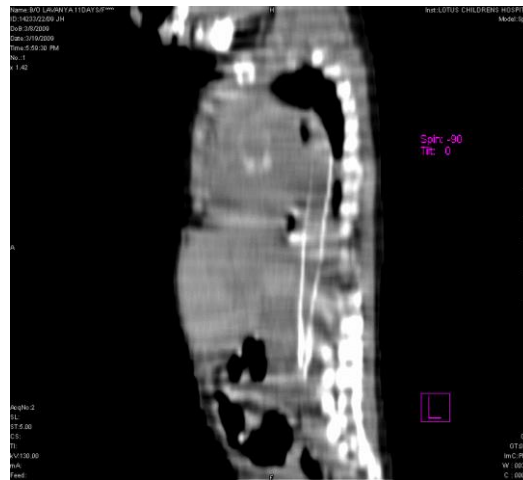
2. Computed tomography abdomen revealed diffuse rim calcification of the entire aorta & its branches
